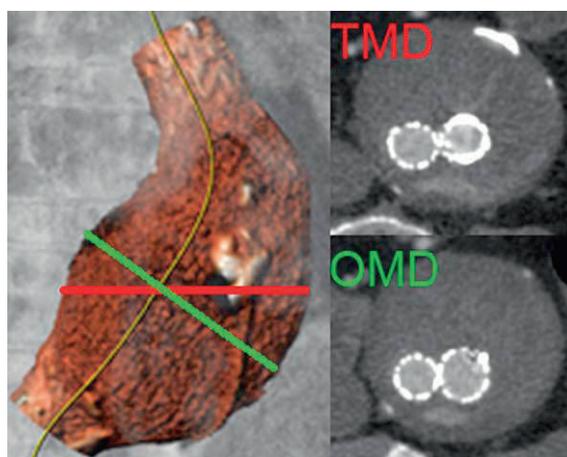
Figure Maximum aortic diameter measurements were taken in the transverse plane (TMD) on axial CTA slices and on a reconstructed plane perpendicular to the center lumen line (CLL, yellow line) for the orthogonal diameter measurement (OMD). Diameter measurements were made independently from each other.
